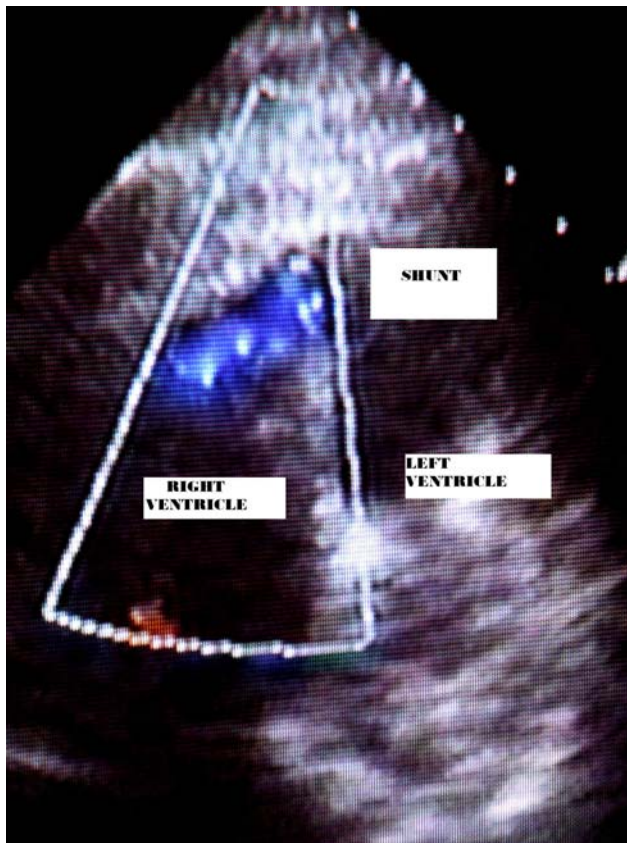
Colour-Doppler echocardiography shows moderate interventricular shunt, from apical four-chamber view
